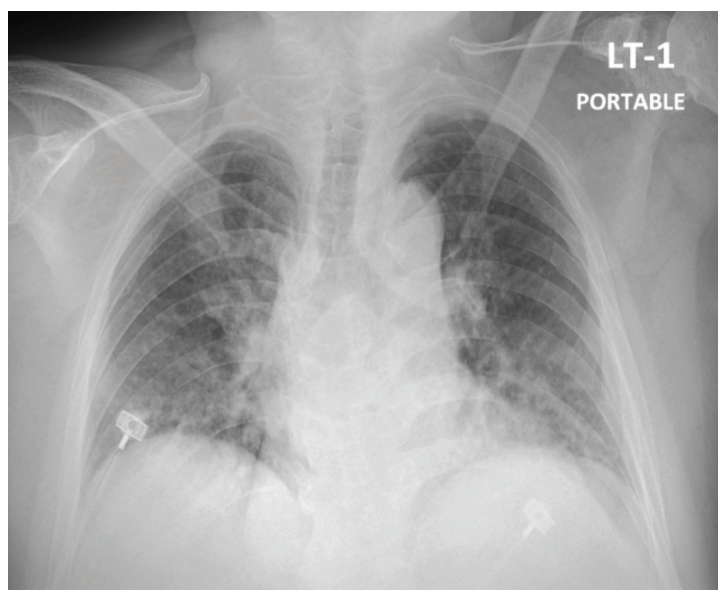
Chest X-ray shows bilateral infiltrates with groundglass opacities and consolidations of a 57-year-old man with COVID-19 pneumonia in a respiratory care unit at Thammasat University Hospital, Thailand (day 6 after onset of illness).
